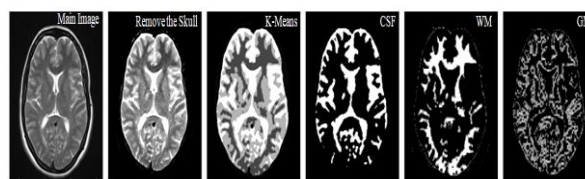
(A): An MRI slice from an MS patient; (B): Improving resolution and brightness and separating the skull from the image; (C): Using the K-means algorithm with three clusters to separate three brain regions; (D) Separating CSF; (E): Separating WM; (F): Separating GM.
